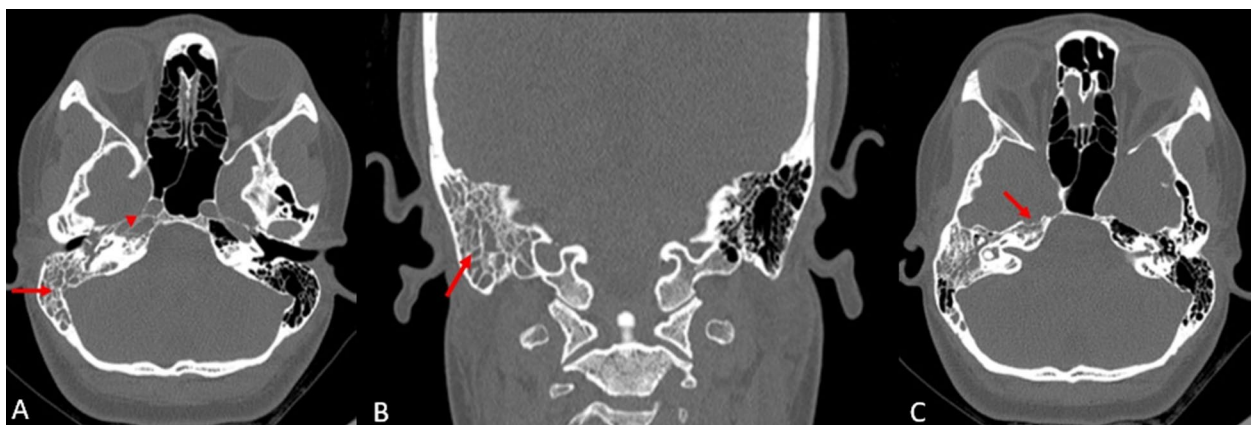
A 26-year-old female presented with history of right sided rhinorrhoea. A Plain CT PNS and temporal bone axial section showing bilateral hyper-pneumatized petrous bones with overcrowding of the right mastoid air cells (red arrow), opacification of the hyper-pneumatized petrous bone (red arrow head) and mild right ethmoid sinusitis. B Plain CT temporal bone coronal section demonstrating the overcrowding of the right mastoid air cells by mucosal thickening (red arrow). C Plain CT PNS and temporal bone axial section demonstrating the scalloping along the antero-medial aspect of the right petrous bone (red arrow)
